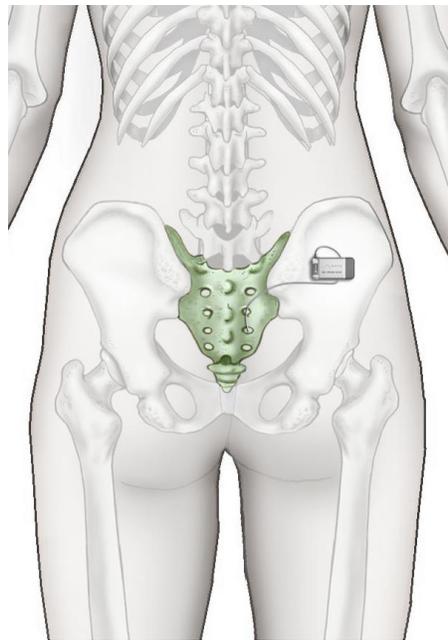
Axonics SNM System implant location eligible for full body MRI
